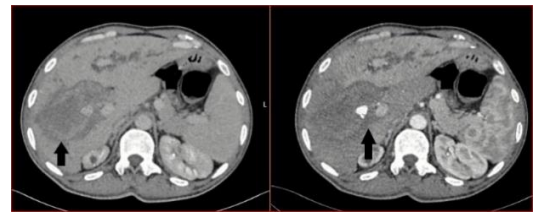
CT images: blood in the cyst in venous phase (left). Hepatic artery pseudoaneurysm in arterial phase (right)
